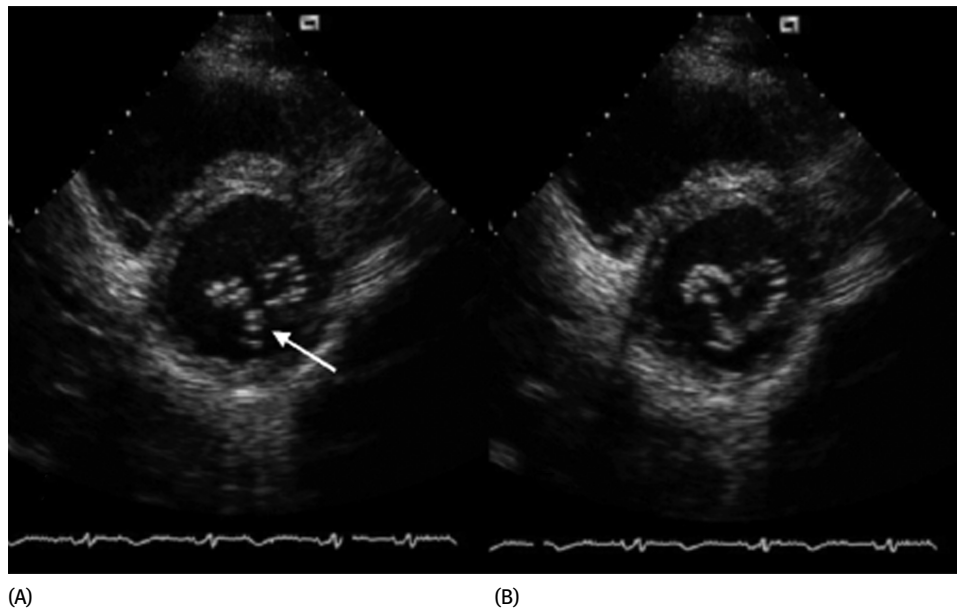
Parasternal short axis view of the mitral valve with a cleft in the segment P2 of the posterior mitral leaflet (arrow). (A) shows the valve in closed position (early systolic still-frame); the cleft looks like a “T.” In (B), the valve is open (early diastolic still-frame).
